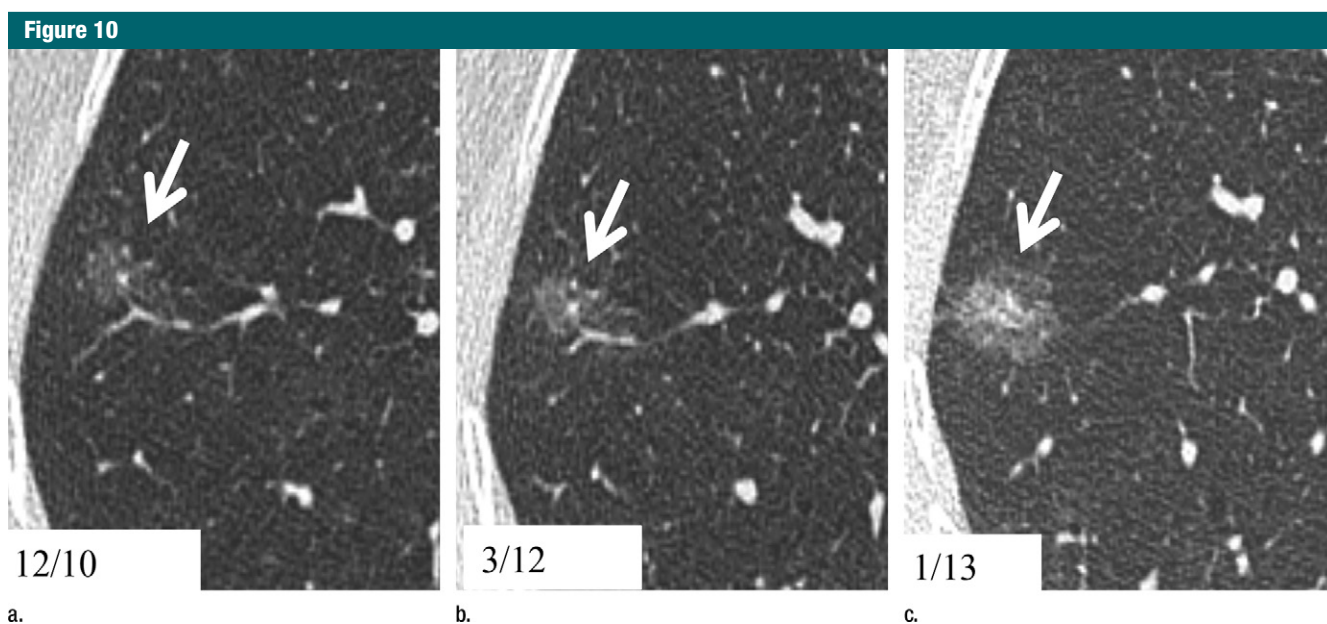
(a) A 1-mm transverse CT image through the right midlung shows a 10-mm pure ground-glass nodule (arrow). (b) CT image in the same location as a at 15-month follow-up shows only a very subtle increase in opacity. (c) CT image in the same location as a and b a further 10 months after b shows the nodule has evolved into a larger part-solid nodule. Surgical resection revealed stage 1A invasive lepidic predominant adenocarcinoma.
